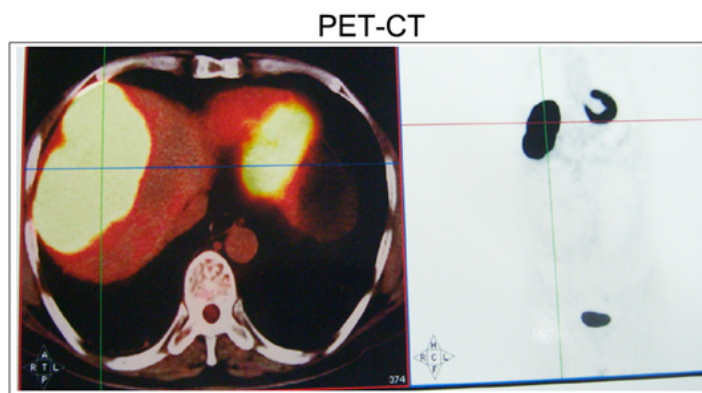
PET-CT scan showing a high glycolytic activity of a solitary mass in the right lobe of the liver, but no spread to the body.
